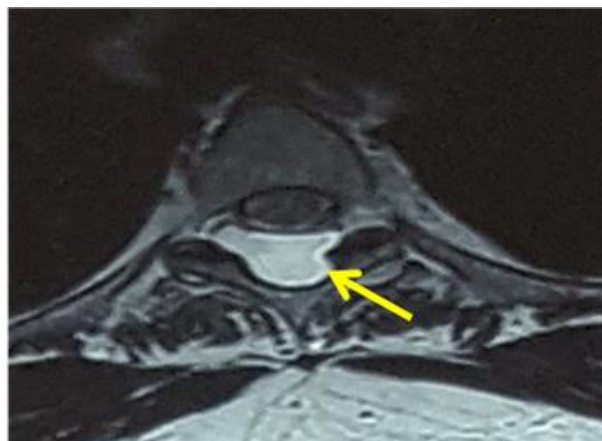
T2-weighted MR imaging sequences showing arachnoid cyst with high signal intensity at T2 to T4 level.
